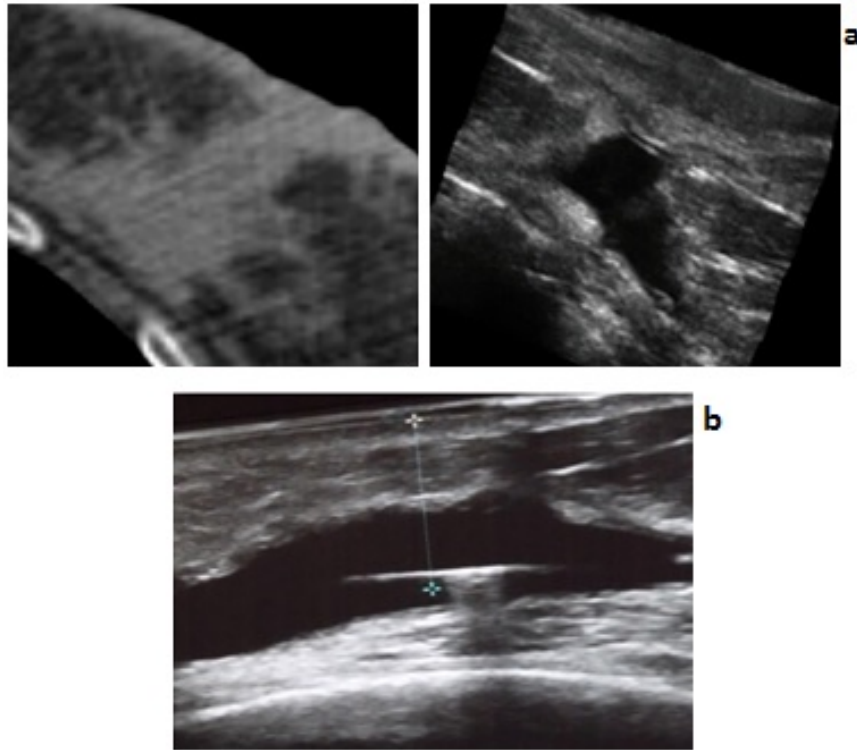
Deficiencies in imaging for PBSI. (a) Visualization of the same seroma visualized on CT (left) and US (right) may appear different in terms of size and shape. (b) The fiducial needle inserted through the center of the seroma, visualized on US, using only subjective interpretation of the surrounding anatomy as a guide. No spatial information relative to the template is available.
